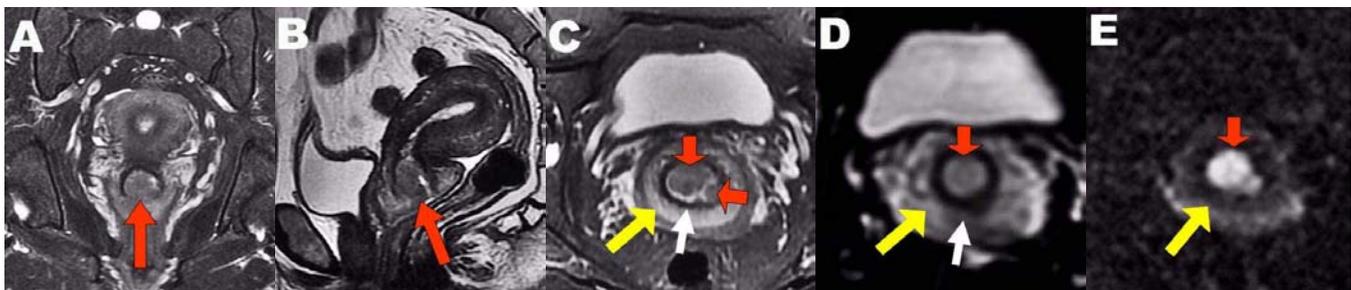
Figure A-E. Cervical squamous cell carcinoma of the uterus in a 54 year-old woman. The tumor showed mildly hyperintense (red arrows) on coronal (Fig A), sagittal (Fig B) and axial (Fig C) FSE T2WI. On axial FSE T2WI (Fig C) and SE-EPI T2WI (b=0 s/mm²) (Fig D), the dark circle stripe (white arrows) represented normal fibrous stroma zone, which was surrounded by smooth muscle strand of medium signal (yellow arrows). On DWI with b value of 1000 s/mm², the malignant tissue showed significantly high signal intensity (red arrow), while the normal tissue around the lesion became dark (yellow arrow). The ADC value of malignant lesion was $0.85 \times 10^{-3} \text{mm}^2/\text{s}$, and that of the normal tissue around the lesion was $1.62 \times 10^{-3} \text{mm}^2/\text{s}$. A tumor of Stage I a was confirmed by surgery.
